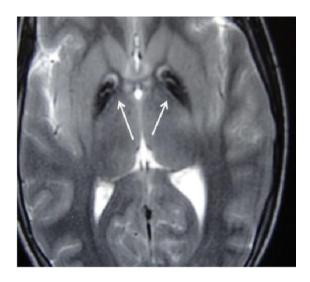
Axial T2 weighted MRI of brain at the level of basal ganglia showing - hypo intense rim surrounding the antero medial hyper intense signal in bilateral globus pallid (white arrows).
